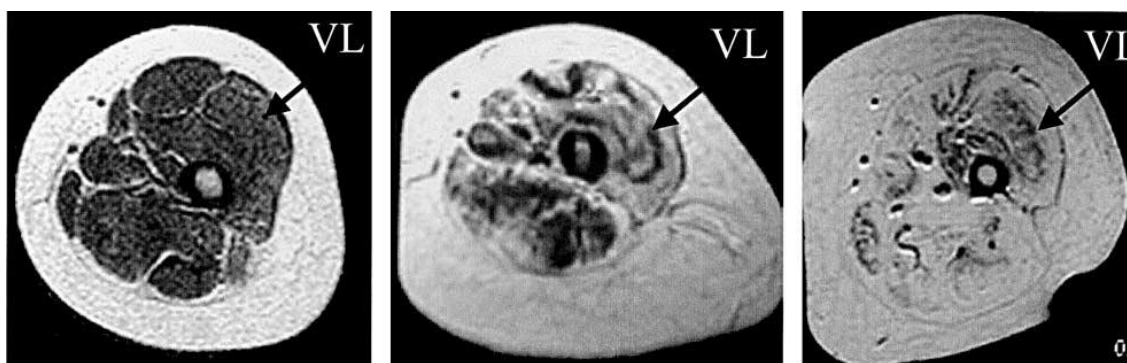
T1w thigh muscle MRI findings in three generations of a family with Bethlem myopathy: Images show the characteristic pattern of muscle involvement in this condition as well as more marked fatty infiltration seen with increasing disease duration. Note that the vastus lateralis (VL) is only marginally affected at its periphery in the 6-year-old young girl (left). The periphery of the same muscle is also more markedly affected in her mother (middle) and in her grandmother with obvious sparing of the central part (right).²
